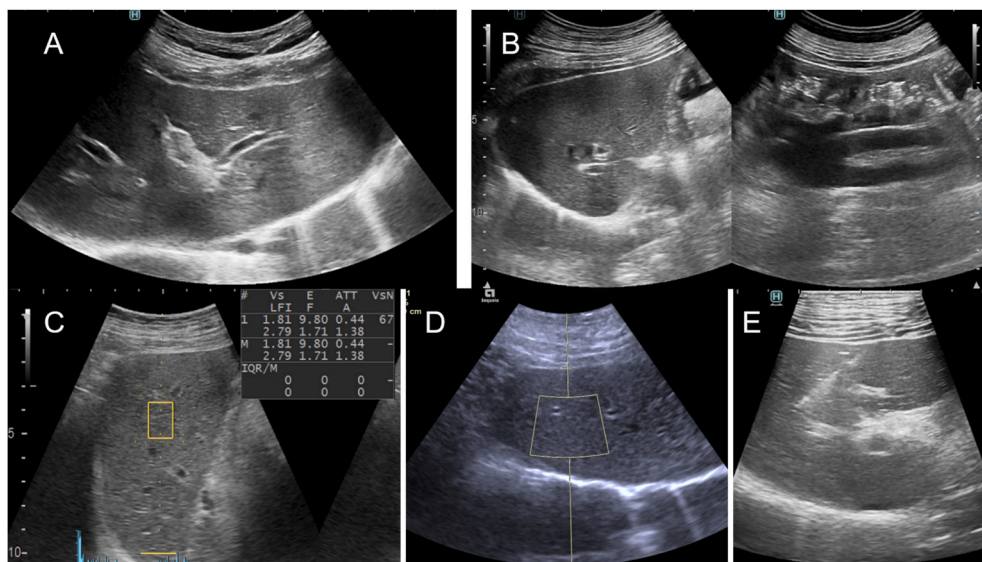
Representative ultrasound images. (A) Two-dimensional image of the liver from Hitachi ultrasound equipment. (B) Two-dimensional image of the liver and kidney under the same parameter from Hitachi ultrasound equipment. (C) Representative image of Hitachi ultrasound equipment ATT measurement. (D) Representative image of Siemens ultrasound equipment UDFF measurement. (E) Screenshot of ultrasound-guided puncture.
